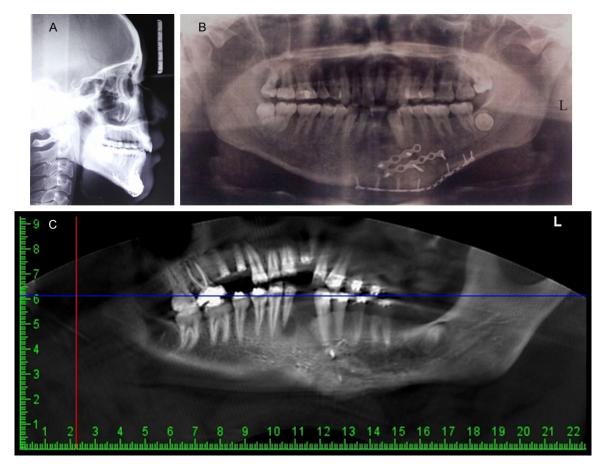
A, B. Preoprative X-rays: A. Cephalomatric radiograph; B. Panoramic radiograph; C. Cone Beam CT shows the existing periapical periodontitis of 42.
